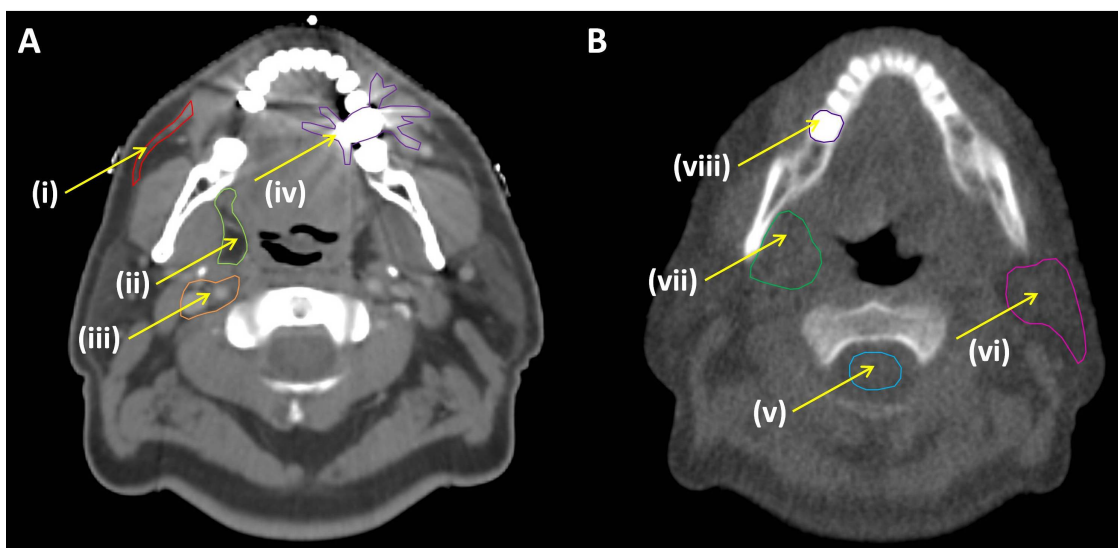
(A&B): Examples of kVCT planning CT scan with IV contrast (A) and image guidance MVCT (B) images (images from different patients). The detail in A allows resolution of detailed soft tissue structures such as parotid duct (i), parapharyngeal fat space (ii) and neurovascular bundle (iii). There is also significant streaking artefact from dental amalgam (iv). The MVCT gives sufficient detail to resolve the spinal cord (v) and parotid gland (vi), but it is very difficult to define the boundary between parapharyngeal space and medial pterygoid muscle (vii). Of note, there is less dental artefact (viii), due to higher energy MVCT X-Rays.
